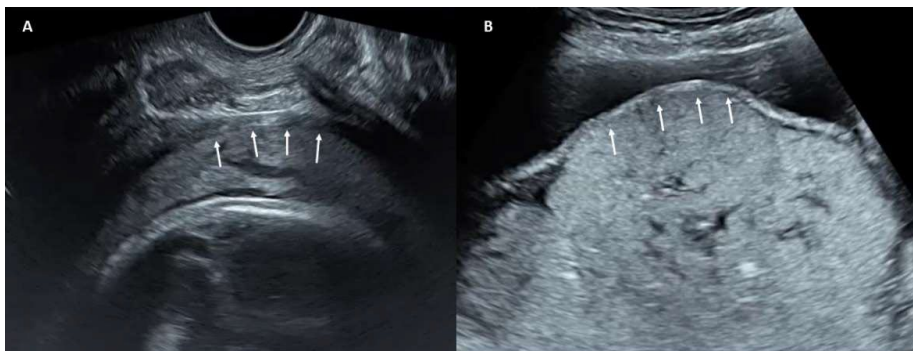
Ultrasound evaluation of the clear zone. A) Case without suspected PAS: the clear zone is correctly identified. B) Suspected PAS: loss of the retroplacental hypoechoic plane or clear zone.
